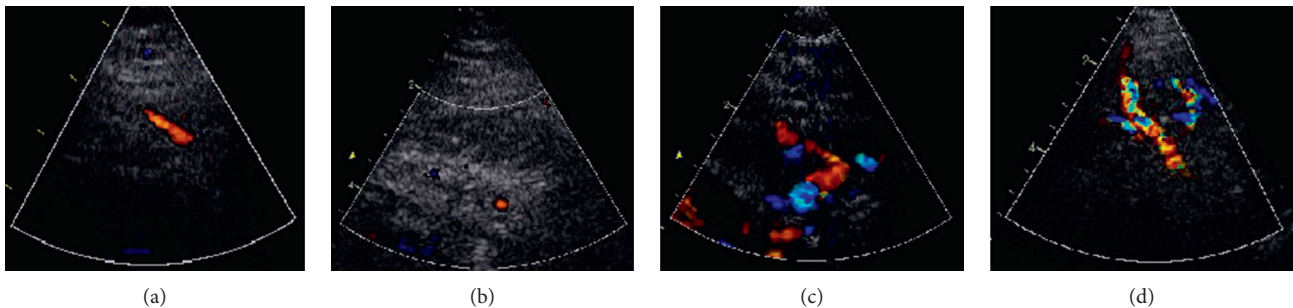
2D color Doppler view of the left anterior descending artery (LAD) demonstrating the importance of artery identification and alignment for accurate CFVR estimation. (a) Optimal visualization of the LAD segment in a foreshortened two-chamber view. Suboptimal artery identification compromising quality of CFVR evaluation: (b) only a short segment of the artery visible; (c) tortuous artery; and (d) multiple vessels in the same frame.
